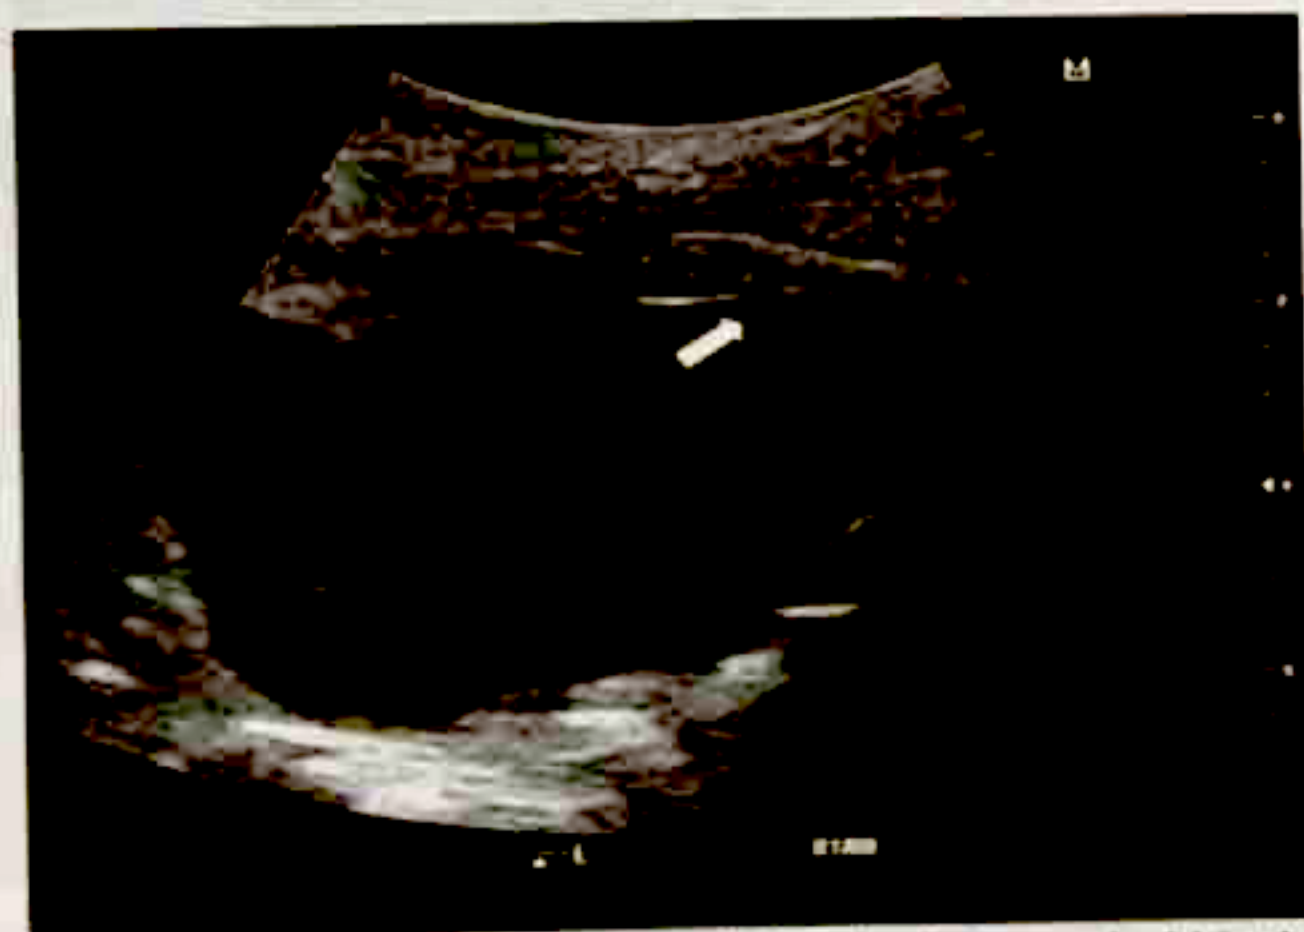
Transperineal ultrasound showing left gonad within the left labioscrotal fold near the inguinal canal.
